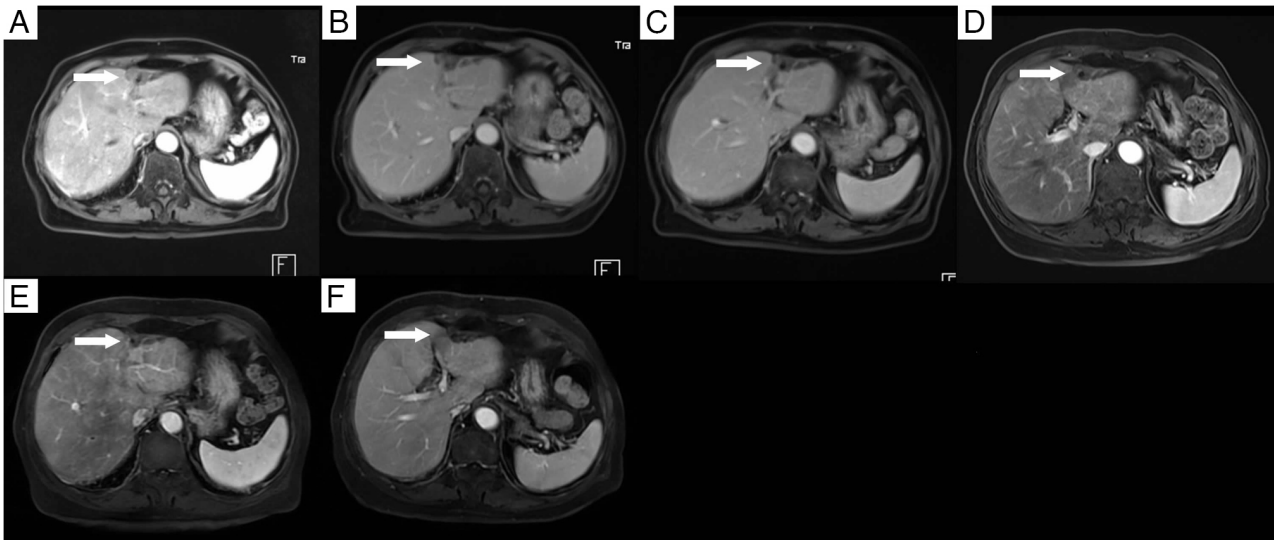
Follow-up by enhanced magnetic resonance imaging. (A) The lesion measured 30x19 mm at 6 years post-HIFU. At (B) 7, (C) 8, (D) 9, (E) 10 and (F) 11 years post-high-intensity focused ultrasound, the left hepatic lobe shows stable residual scar tissue without signs of recurrence.
